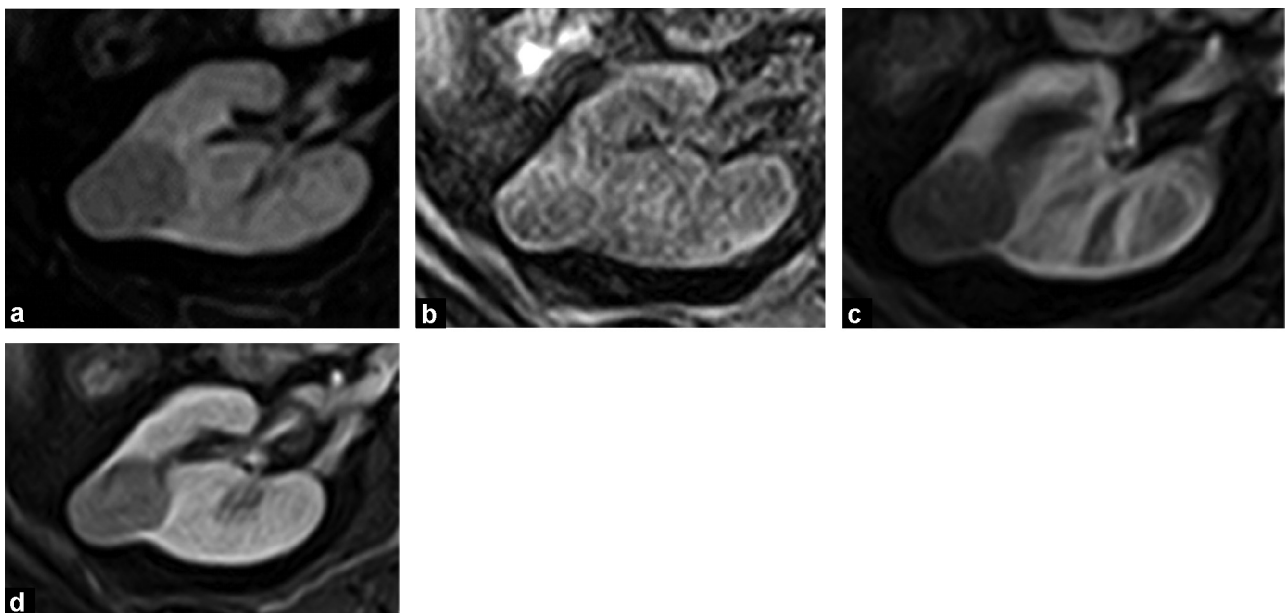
Typical MRI appearance of a papillary carcinoma: small homogeneous, well demarcated tumor, hypointense on T2 weighted image, enhancing weakly (65%) but significantly; a: MRI: T2 weighted image; b: MRI: unenhanced T1 weighted image; c: MRI: T1 weighted image, arterial phase; d: MRI: T1 weighted image, tubular phase.
